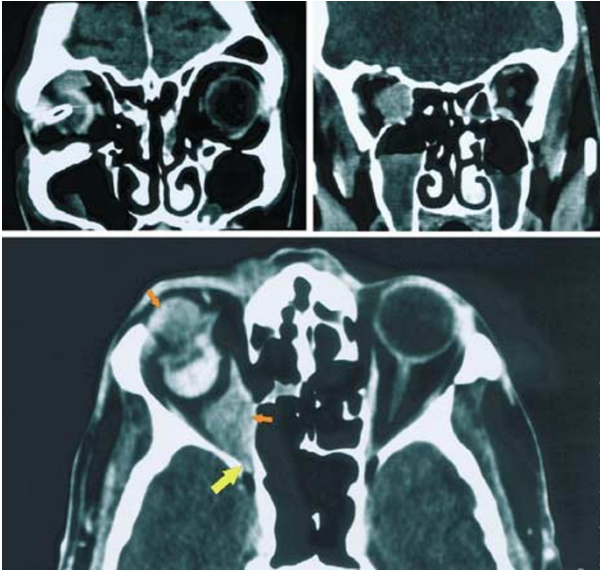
(Top left) Coronal CT-scan showing a mass anteriorly localized in the right superior rectus muscle depressing the Allen implant and the prosthesis. (Top right) Coronal CT-scan demonstrating a posteriorly located mass in the medial rectus muscle. (Bottom) Axial CT-scan showing two lesions in the superior and medial rectus muscle (small orange arrows). Note the tumour extension in to the optic nerve canal (big yellow arrow).
